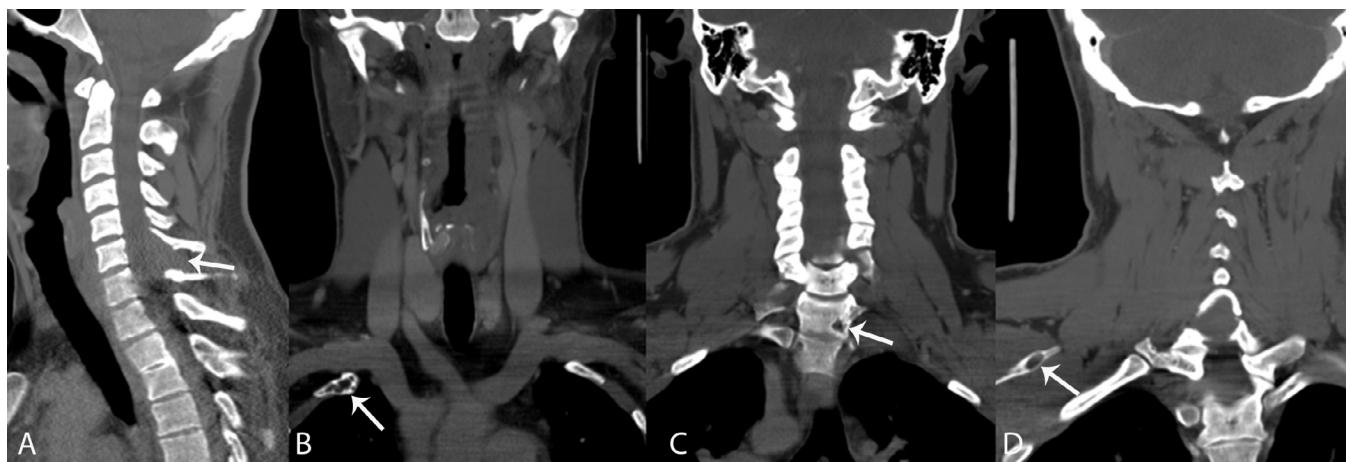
Sagittal reformatted CT image (A) showed a destructive vanishing bone tumor in the C6 posterior elements (arrow). Coronal reformatted CT images showed small lucent lesions (arrows) in the right scapula (B), vertebra (C), and second right anterior costa (D).
